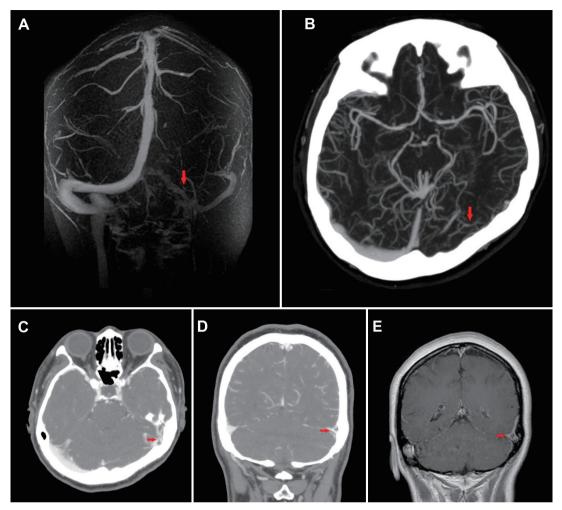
The patient's left transverse sinus was not visible on magnetic resonance venography (A, arrow). Computer tomography venography revealed patulous appearance (B, arrow), and filling defect (arrows in axial and coronal view, C and D) in the distal left transverse sinus, with partial thrombosis. The T1-weighted post-contrast magnetic resonance image showed a filling defect (E, arrow) in the corresponding area. No imaging modality suggested abnormalities of the grey or white matter, and no obvious parenchymal lesions were detected.
